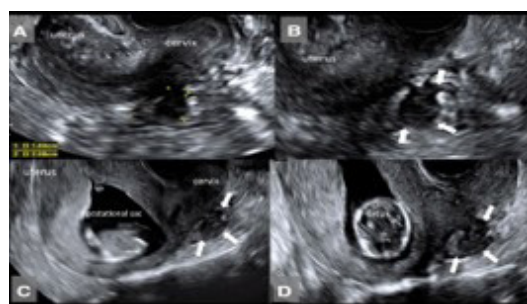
Ultrasound image from a patient with a rectal deep endometriotic lesion who became pregnant spontaneously at 3 months after the transvaginal sonography (TVS) scan for tubal patency testing (hysterosalpingocontrast sonography)
